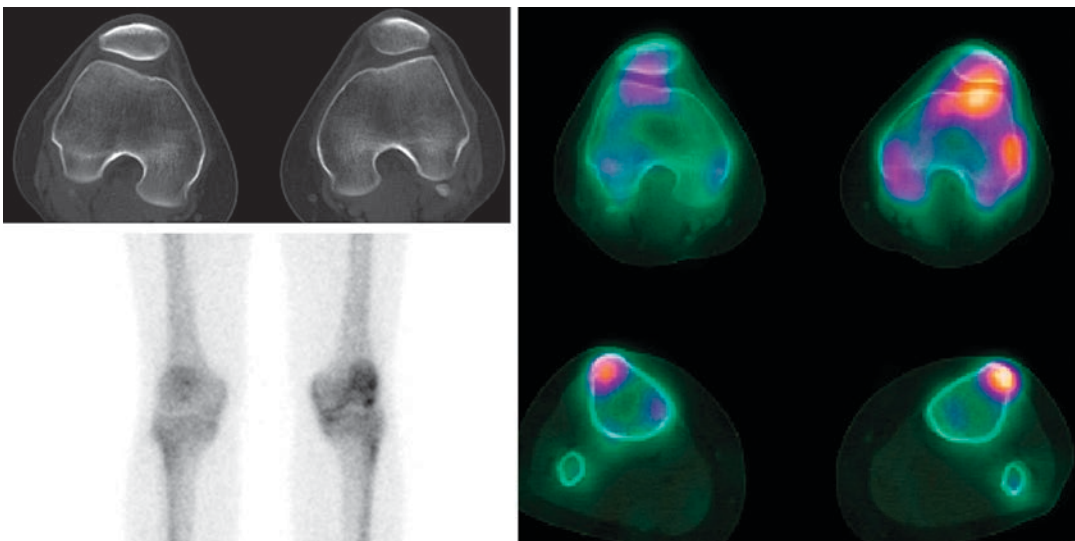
SPECT-CT in an AKP patient with 40° of external tibial rotation. External tibial rotation increases pressure on the lateral side of the PFJ
